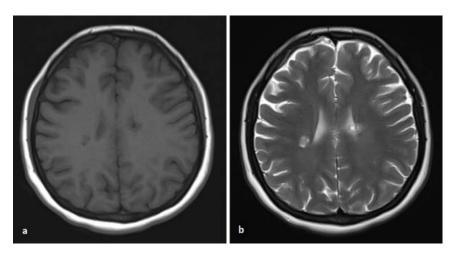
Follow-up MRI shows remarkable reduction in size of both lesions. The lamellae seems shrunken on both T1 (a) and T2-weighted (b) images. T2-hyperintense rings of acute stage appears to be changed to focal, milimetric, hyperintense areas (b).
